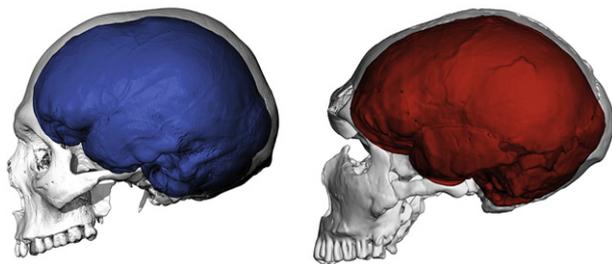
CT scans of a modern human and a Neandertal adult (La Ferrassie 1). Neandertals have elongated braincases and endocasts when compared with modern human adults. Neandertal faces are larger and more projecting than in *Homo sapiens*.
